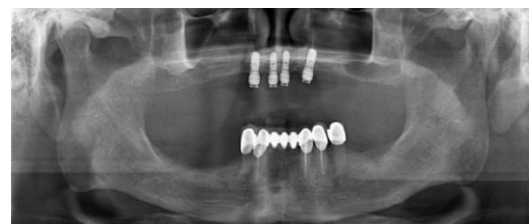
1 year follow-up radiograph with locator abutments
